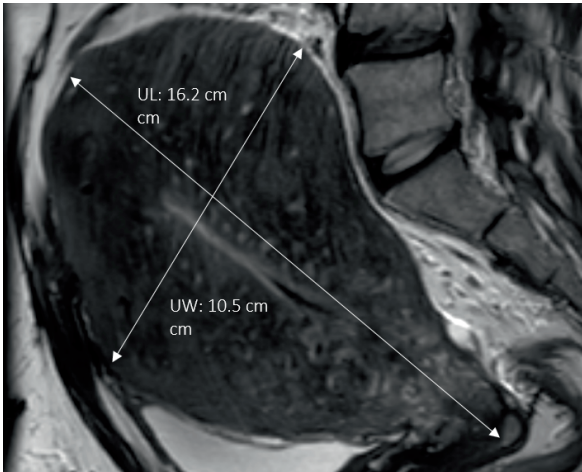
Sagittal T2W MRI showing an enlarged, diffusely adenomyotic uterus, with a uterine length (UL) of 16.2cm and a uterine width (UW) of 10.5cm
